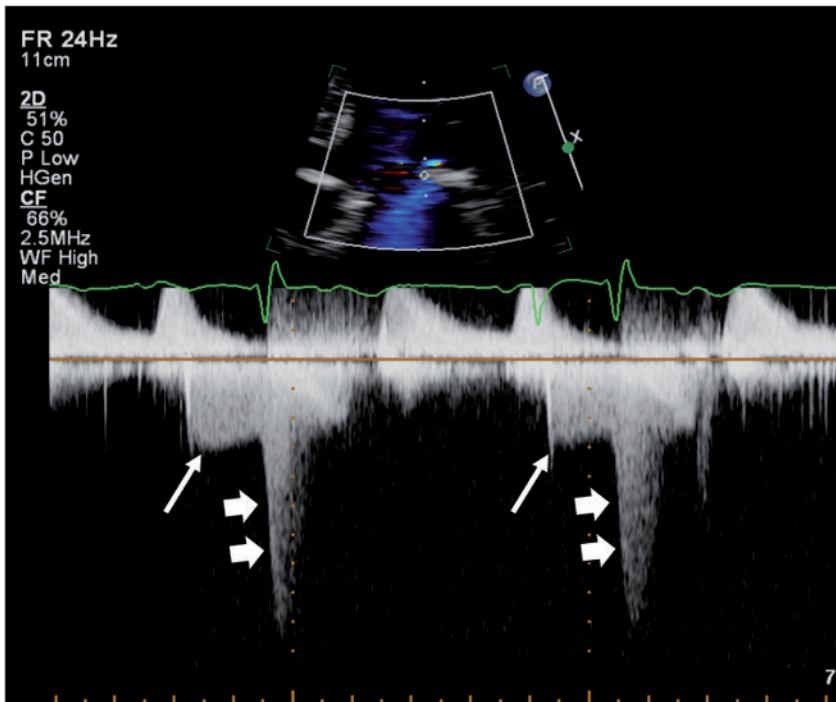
Continuous-wave Doppler through the mitral valve, demonstrating both diastolic (long arrows) and systolic MR (short arrows).
